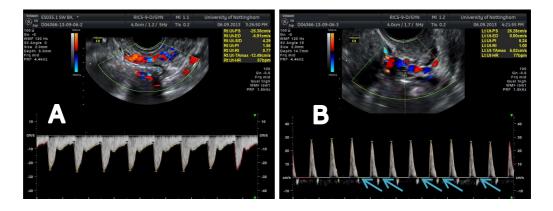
Examples of normal and abnormal pulse wave Doppler of uterine arteries.
